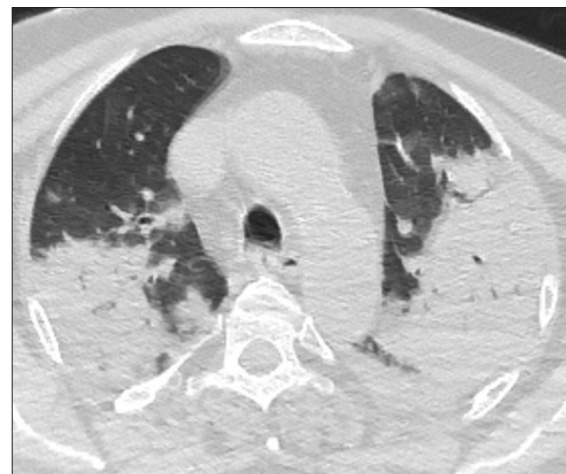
A 74-year-old male COVID-19 patient presenting with fever, chills and cough for 7 day. A CT scan shows bilateral extensive consolidations. The patient died 10 days later
